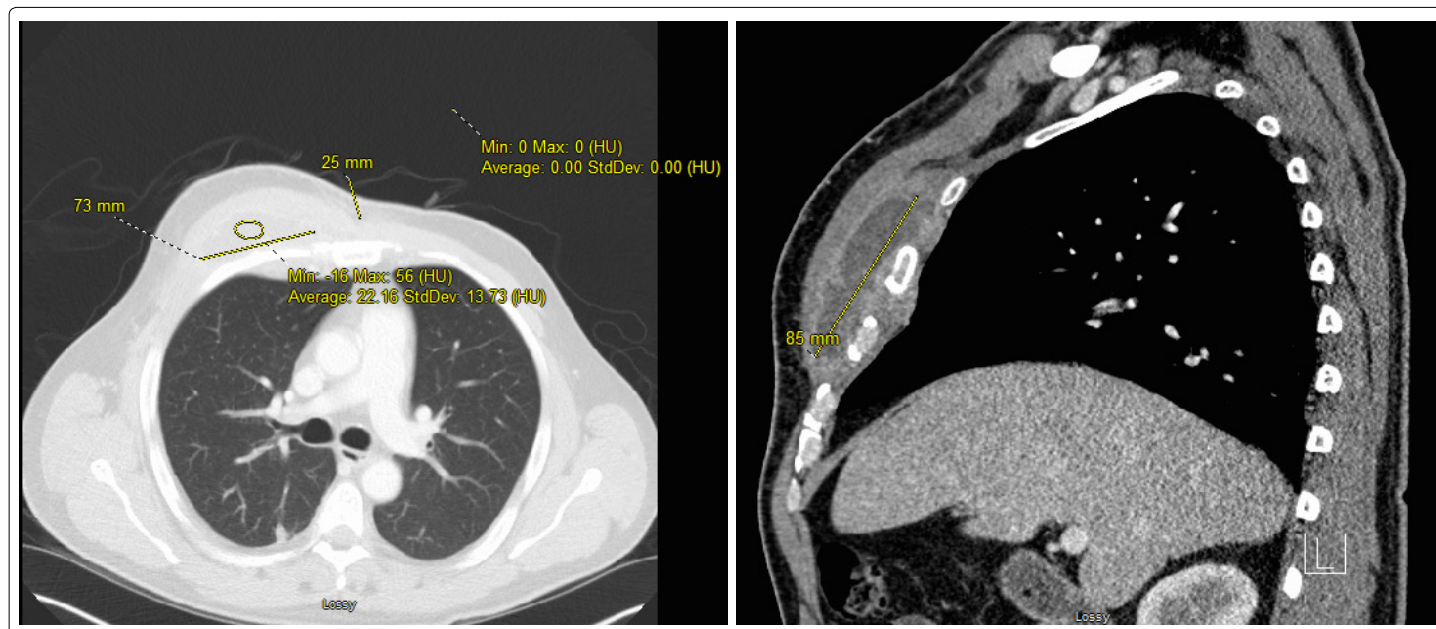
CT chest showed: Right sided chest wall abscess measuring 7cm by 2 cm by 9 cm.
